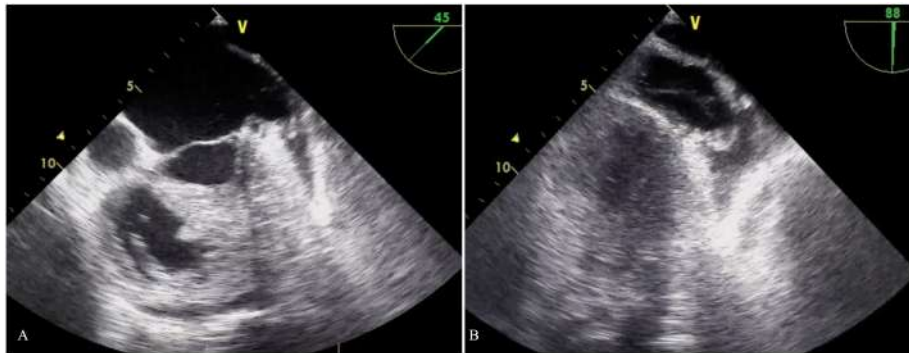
Transesophageal echocardiography of the left atrial appendage. (A) View at 45° demonstrating dense echogenic material within the left atrial appendage. (B) View at 88° confirming persistent echogenic appearance suspicious for spontaneous echo contrast versus thrombus.
